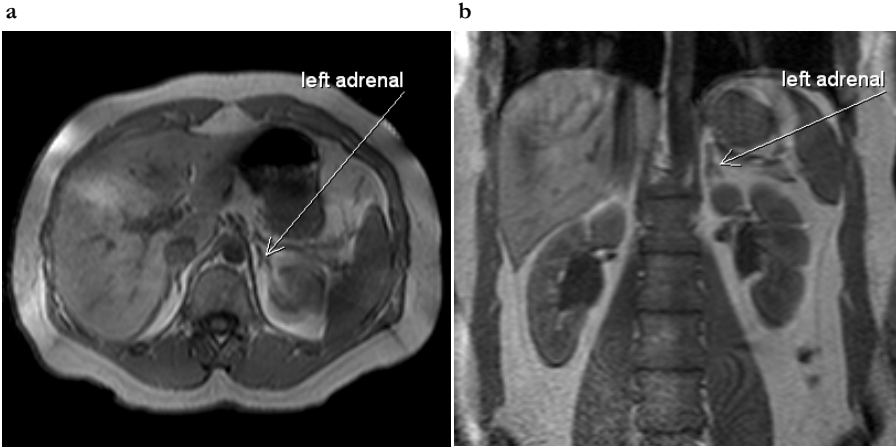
T1-weighted MRI gradient echo (GE) sequence in the transaxial (a) and coronal (b) plane of the upper abdomen at the level of the adrenals. Note black boundary artifacts at the periphery of organs, such as liver and kidneys.
